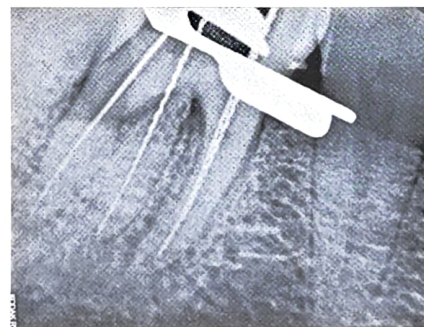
CASE I: Working length radiograph
